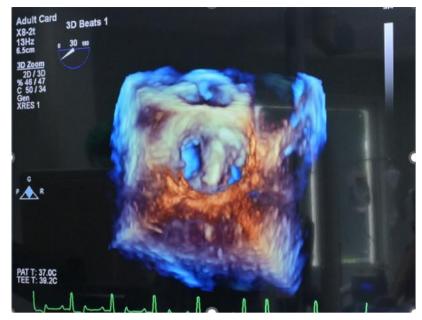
A three-dimensional transesophageal en-face view of the mitral valve with a V-clamp device located at A2-P2 of the mitral valve.
